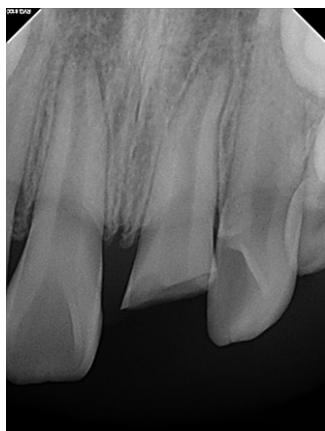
Preoperative periapical view showing the extent of fracture.
